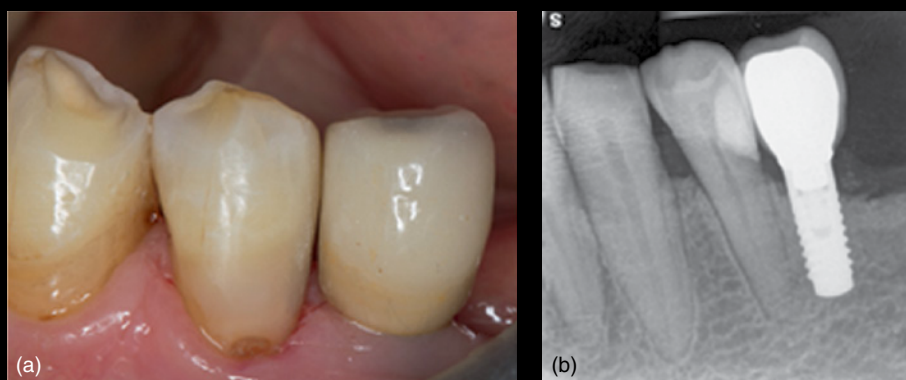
(a) Buccal view of the restored tooth. The interproximal contour and contact point were optimised to prevent food trapping and allow the facilitated interproximal cleaning. (b) Final periapical radiograph.
